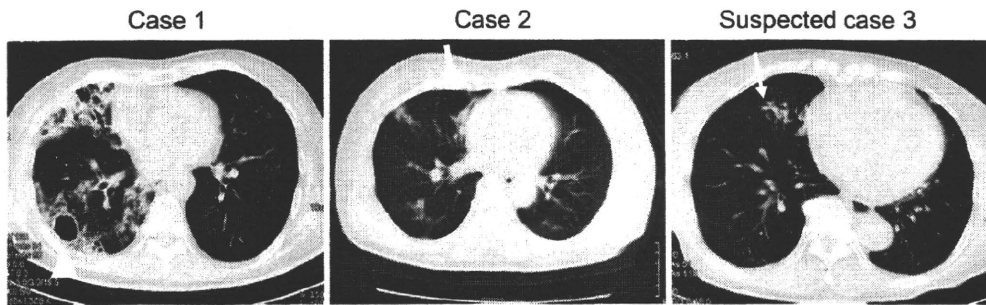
Computed tomography findings of Case 1, Case 2, and Case 3. Chest computed tomography (CT) scan demonstrates multiple, small, peripheral pulmonary nodules centred on the bronchovascular tree, cylindrical bronchiectasis, a cavitary lesion, and consolidations in Case 1 at the age of 69 years. The cavitary lesion, indicated by the arrowhead, resulted from expansion of the bronchiectatic lesion in Case 1. Multiple, small, peripheral, pulmonary nodules centred on the bronchovascular tree and cylindrical bronchiectasis are seen in Case 2, indicated by the arrow (at the age of 69 years). Nodular and centrilobular granular shadows are observed in Case 3, indicated by the thin arrow (at the age of 82 years). The CT scan findings of Case 1 are more severe than those of both Case 2 and Case 3.
